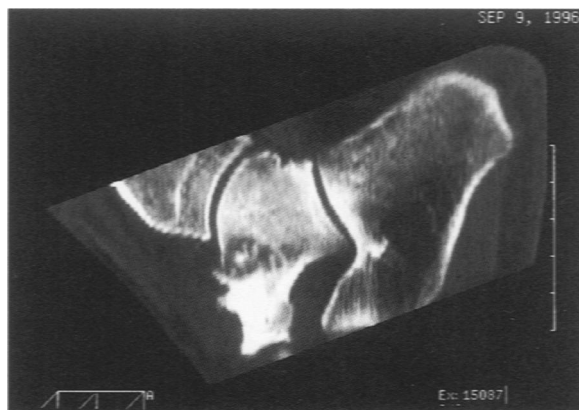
Two-dimensional reconstructions in the sagittal of the preoperative CT scan of the right ankle showing the hyperostotic-appearing zone of previous surgery and, above and below this region, a lytic zone with some calcifications or ossifications in the centre, suggesting a locally recurrent osteoid osteoma (case no. 2)
